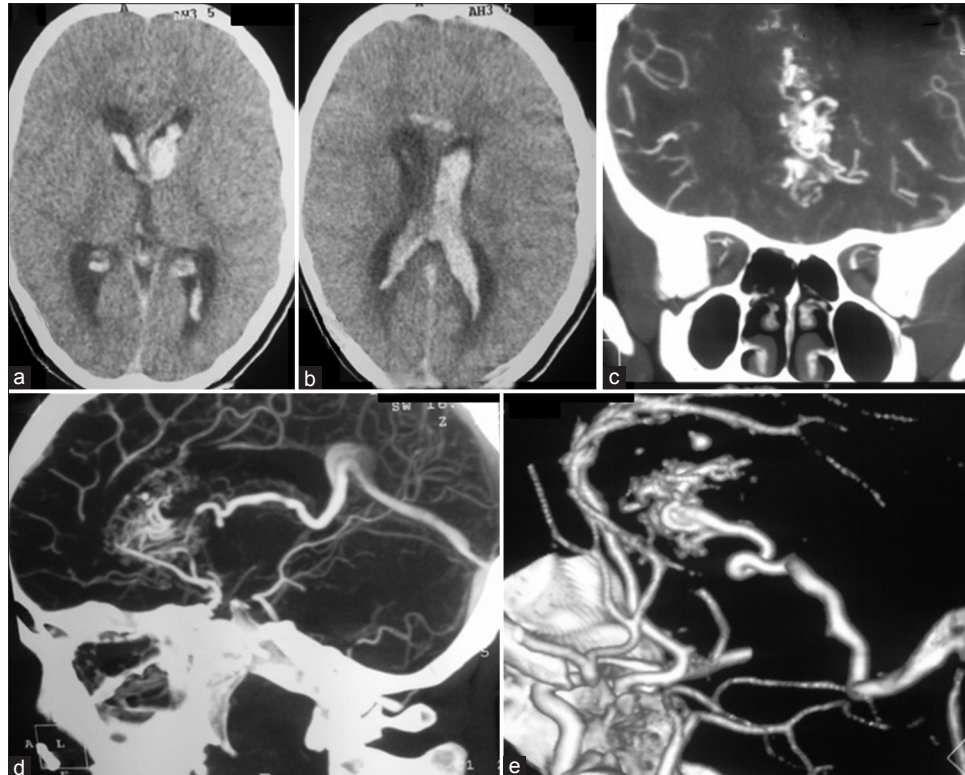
(Patient 12): (a and b) Axial CT scan showing intraventricular and corpus callosal bleed; (c) AP view; and, (d and e) lateral view of CT angiogram showing an intranidal aneurysm and deep seated caudate nucleus and intraventricular AVM supplied by ACA and its perforators and draining into the superior sagittal sinus and via the internal cerebral vein into the straight sinus
